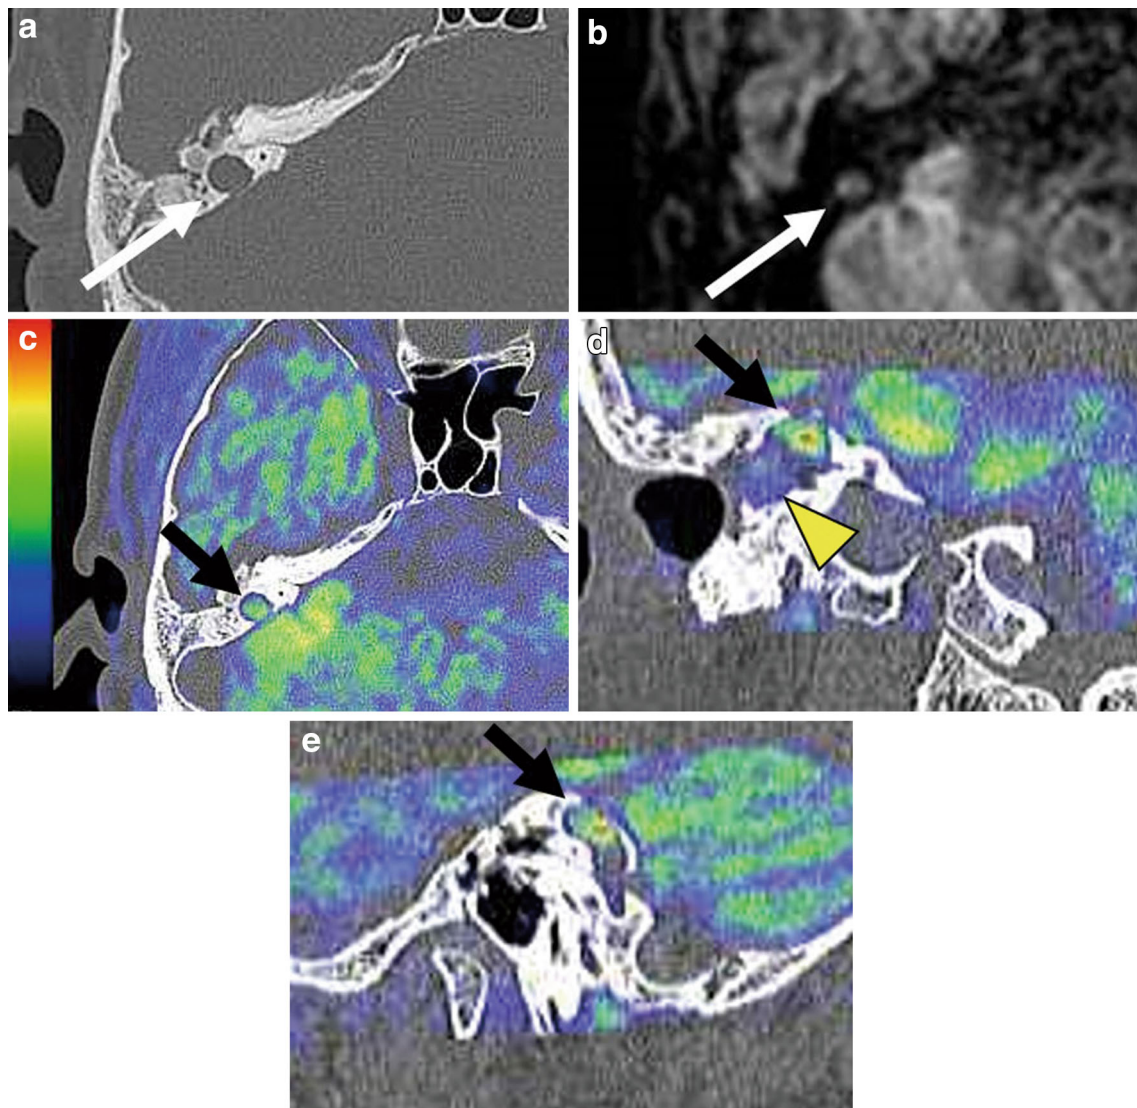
A 38-year-old male with recurrent cholesteatoma in the right middle ear. a CT, b TFE-DSDE, c axial fused image, d coronal fused image, e sagittal fused image. On CT, a low-density lesion is located in the supralabyrinth. On TFE-DSDE, a nodular lesion with hyperintensity suggestive of cholesteatoma is visualized (arrow).
